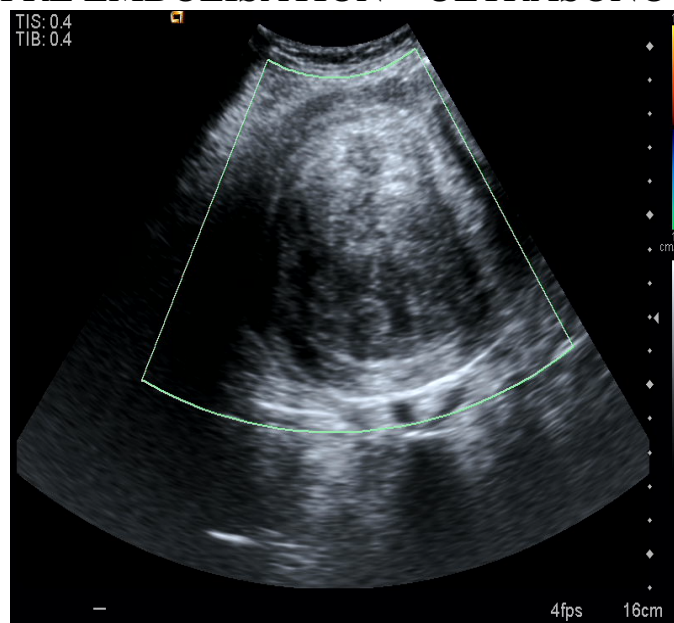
PRE EMBOLISATION - 2D COLOR DOPPLER
